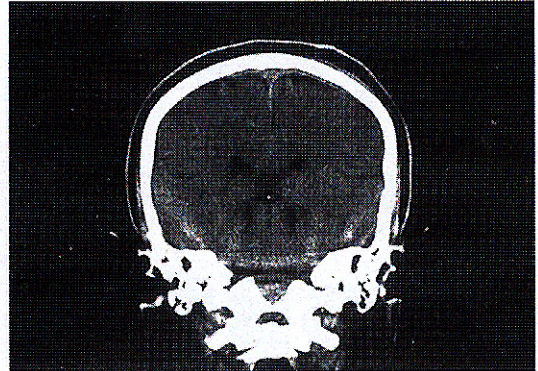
Postoperative coronal CT scan through the vertex demonstrates near complete evacuation of the hematoma.
